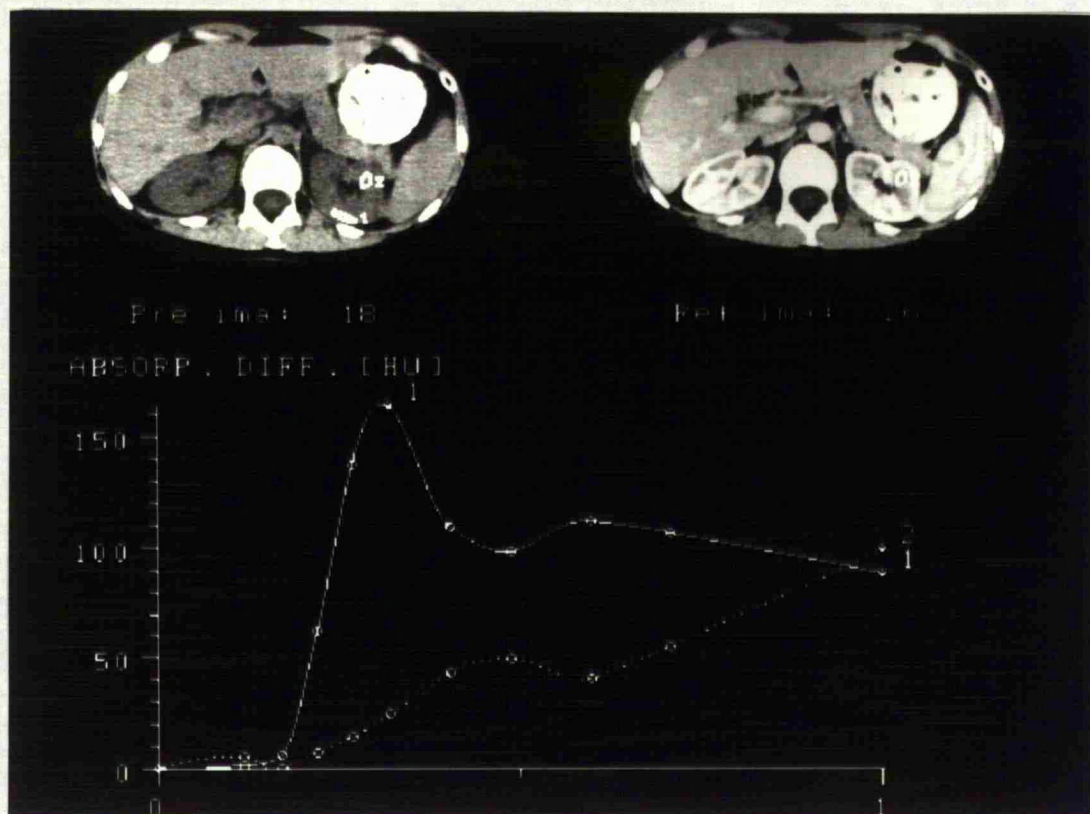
Supp: Renal cortical and medullary TDCs from the Siemens Somatom Plus CT system (Addenbrooke's Hospital).
